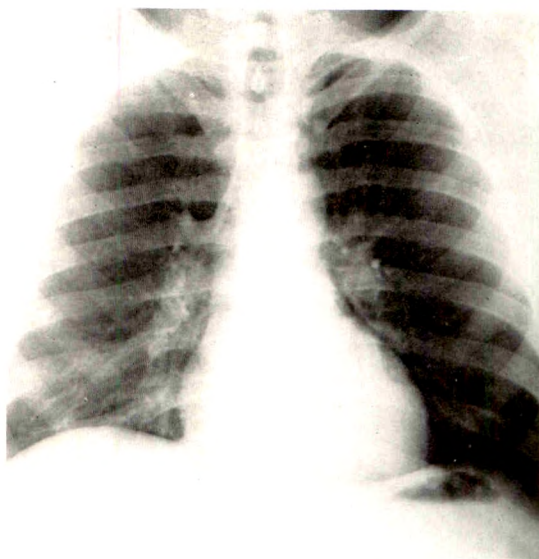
Case II. October 16, 1959: Progress roentgenogram 10 days following second admission.
